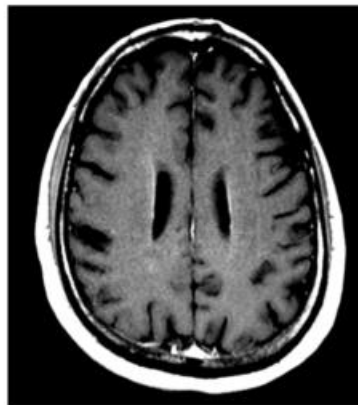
Two week follow up T1-weighted MRI brain with contrast demonstrates marked decrease in periventricular curvilinear enhancement with mild residual enhancement.
